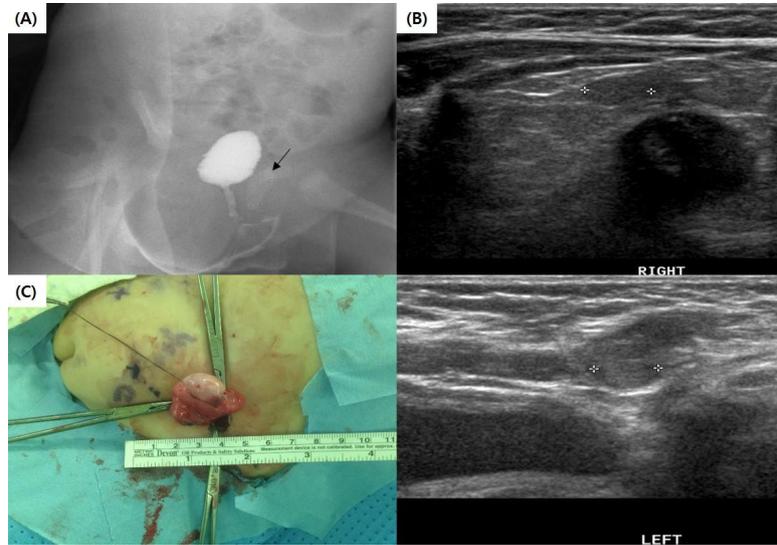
(A) No fistula was visualized when contrast was injected into the common urethra, and a short blind-ended vaginal pouch (arrow) was found on genitography. (B) Pelvis sonography revealed both testes. (C) Both testes were subsequently dissected and removed.
